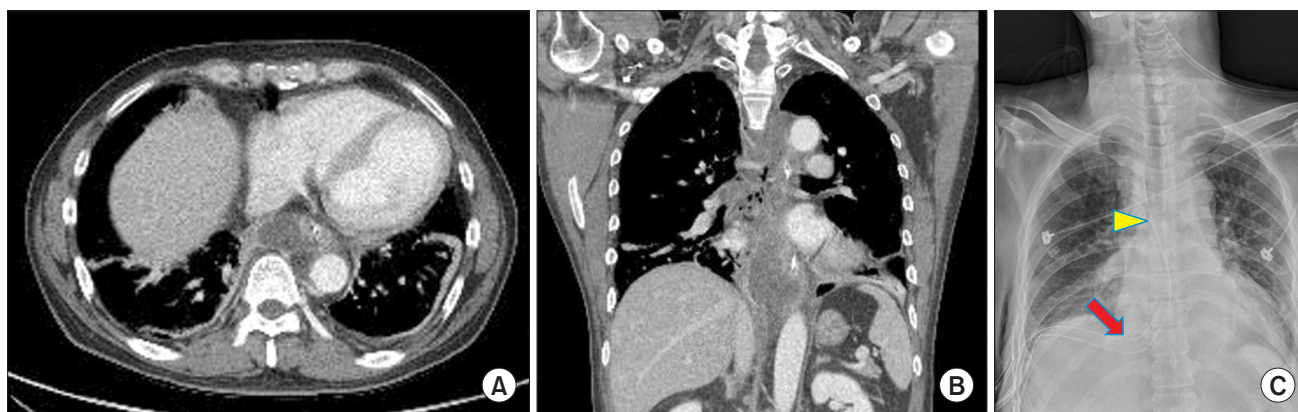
Representative images of a 50-year-old male patient with Endo type II descending necrotizing mediastinitis. Preoperative axial (A) and coronal (B) computed tomography images show an abscess with gas shading in the prevertebral (paraesophageal) space invading the lower posterior mediastinum. (C) A postoperative chest X-ray obtained immediately after surgery showing the chest tubes located in the upper (arrowhead) and lower (arrow) mediastinal spaces.
